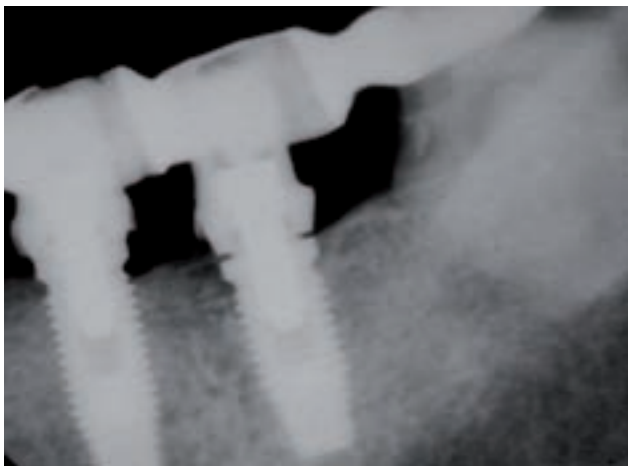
Radiograph of an abutment on an externally hexed implant that is not completely seated.
